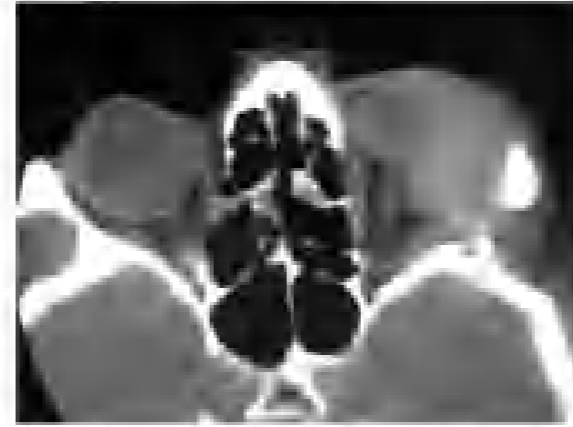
Axial computed tomography (CT) scan showing a well-defined mass displacing the globe inferiorly, infiltrating the lateral wall of the globe, lateral rectus muscle, and lateral bone.
